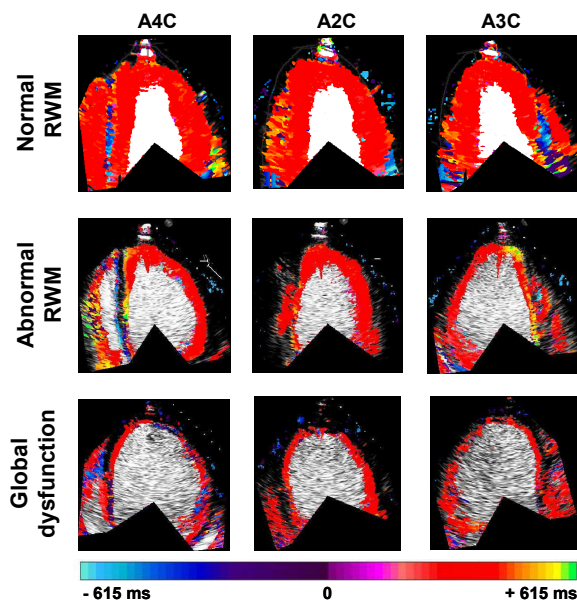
Examples of mean transition time images obtained in the apical 4-chamber view (A4C), 2-chamber view (A2C), and 3-chamber view (A3C) in a patient with normal wall motion (top), a patient with RWM abnormalities (middle), and a patient with global LV dysfunction due to dilated cardiomyopathy.
